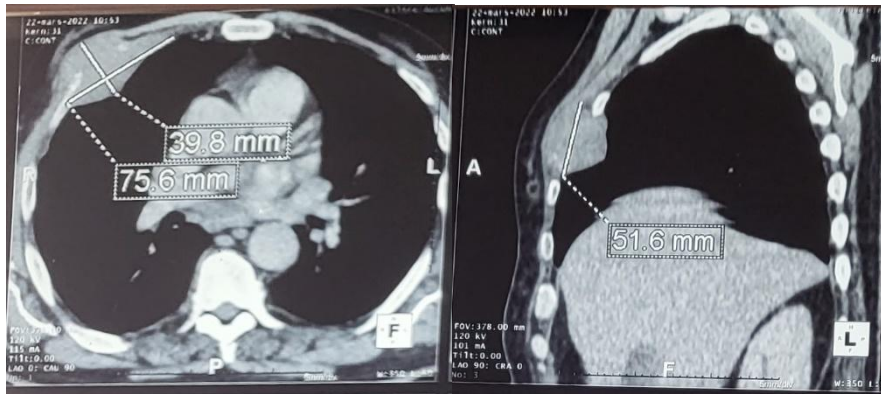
Axial and sagittal sections of a thoracic CT scan revealing a large parietal osteolytic mass centered on the 4th costal arch.
